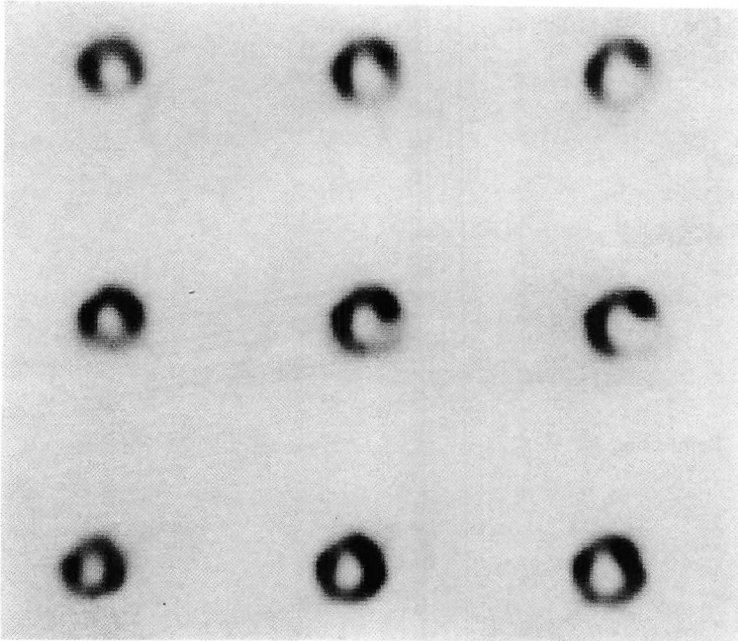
Three representative short-axis slices of stress (top), 3 hour delayed (middle) and reinjection (bottom) thallium-201 SPECT images of a patient with inferior wall myocardial infarction.
